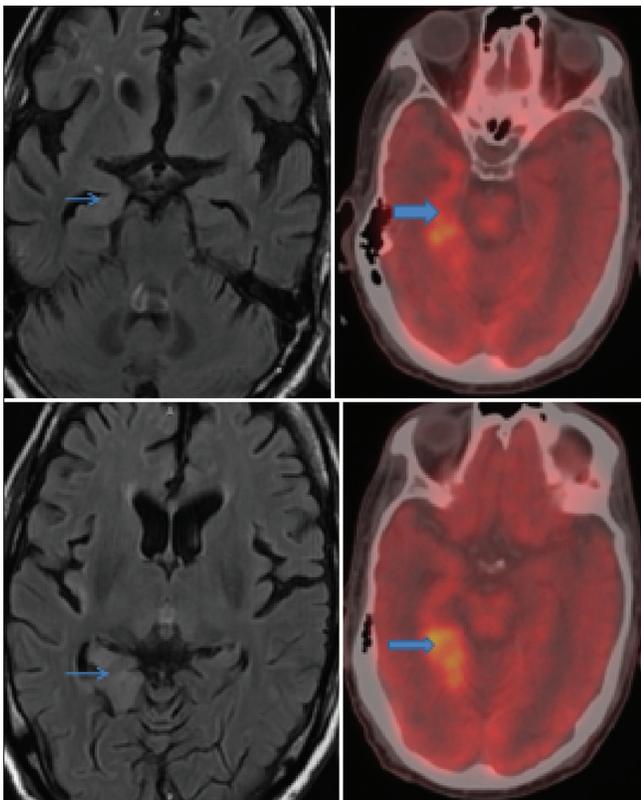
Magnetic resonance imaging (MRI) and positron emission tomography computed tomography (PET-CT) brain show T2-weighted fluid-attenuated inversion recovery sequence axial view hyperintensities involving right temporal gyrus (MRI – small arrow, PET-CT – thick arrow).
